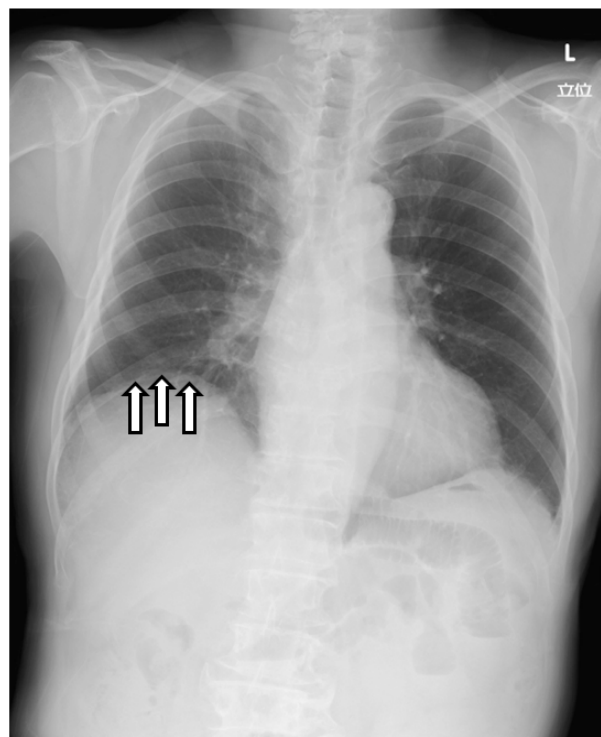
Chest radiograph before anesthesia. Small elevation of the right diaphragm was pointed out (arrow).
